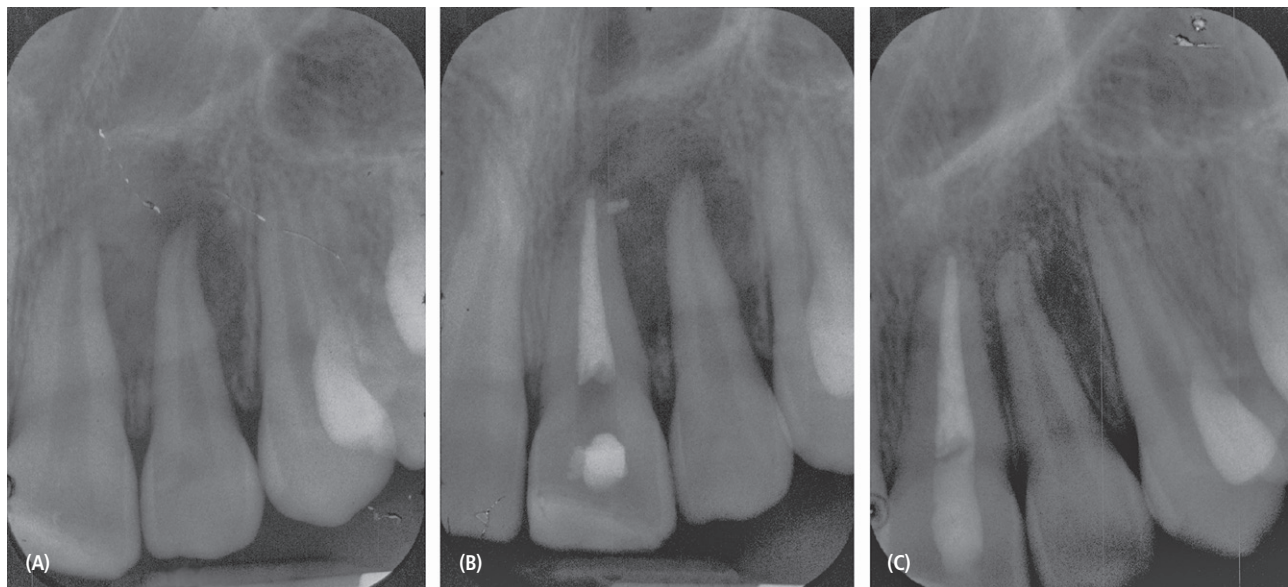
A. Preoperative PA radiograph showing the PA radiolucency of teeth 9 and 10. B. Post-endodontic treatment PA radiograph showing completed RCT of tooth 9. C. One year post-endodontic treatment PA radiograph showing resolution of PA radiolucency of teeth 9 and 10.
